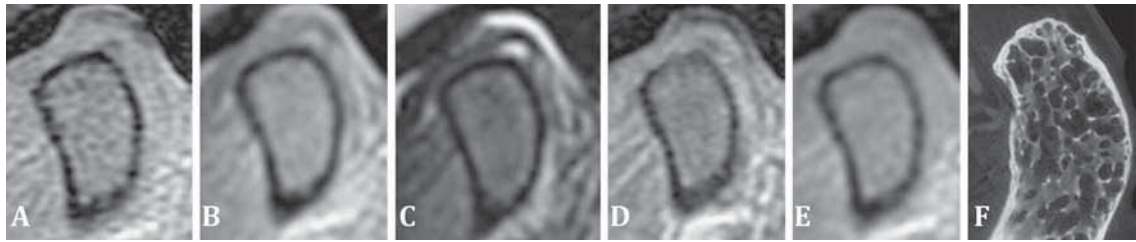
a 2D fast spoiled gradient recalled echo (2D FSPGR), b intermediate-weighted proton density fast spin echo (PD-FSE), c T2-weighted fast spin echo (T2-FSE), d T1-weighted 3D fast spoiled gradient recalled echo (T1-3D-FSPGR) and e T1-weighted fast spin
